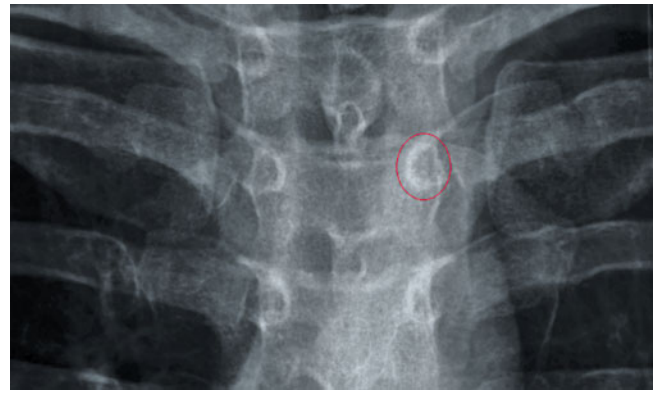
Anterior-posterior X-ray of the thoracic spine demonstrating the “bull’s eye” target for placement of percutaneous pedicle screws. Pedicle is outlined by the highlighted circle
